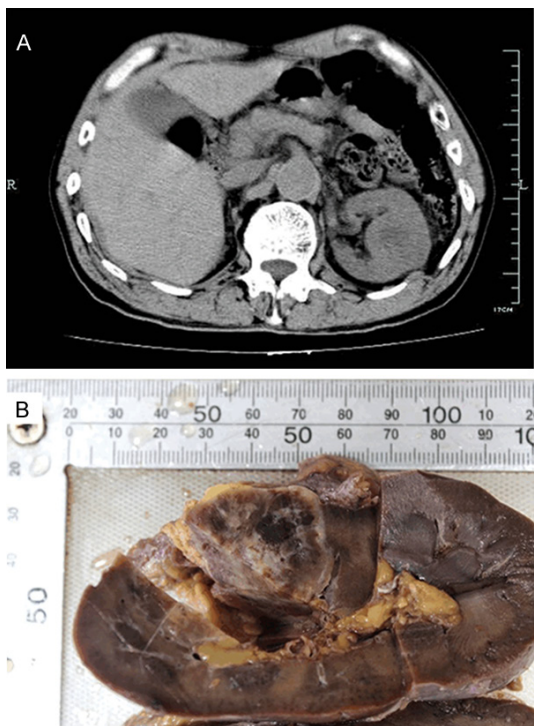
Computed tomography reveals a well-circumscribed and heterogeneous mass in the left mid-kidney of case no. 2 (A). Macroscopic examination shows a 4.8 × 4.3 × 4.0 cm, solid, rubbery and gray-tan mass with gray white fibrotic centrally in case no. 4 (B).
